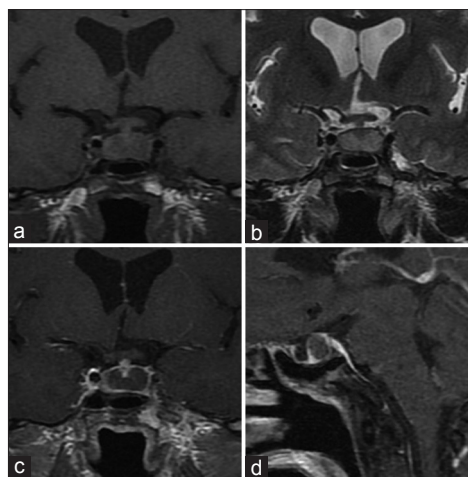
T1-coronal MRI (a). T2-coronal MRI (b). T1-coronal (c) and sagittal (d) MRI with contrast showing rim enhancement of the lesion. MRI: Magnetic resonance imaging.
